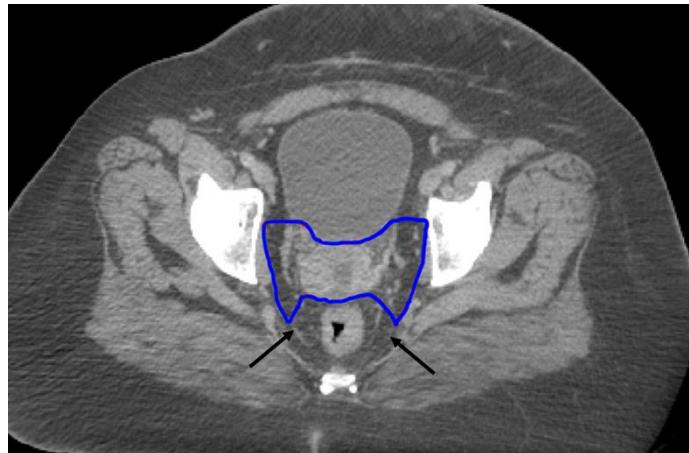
Axial CT demonstrating the uterosacral ligaments (arrowed) and CTV1 (outlined)
